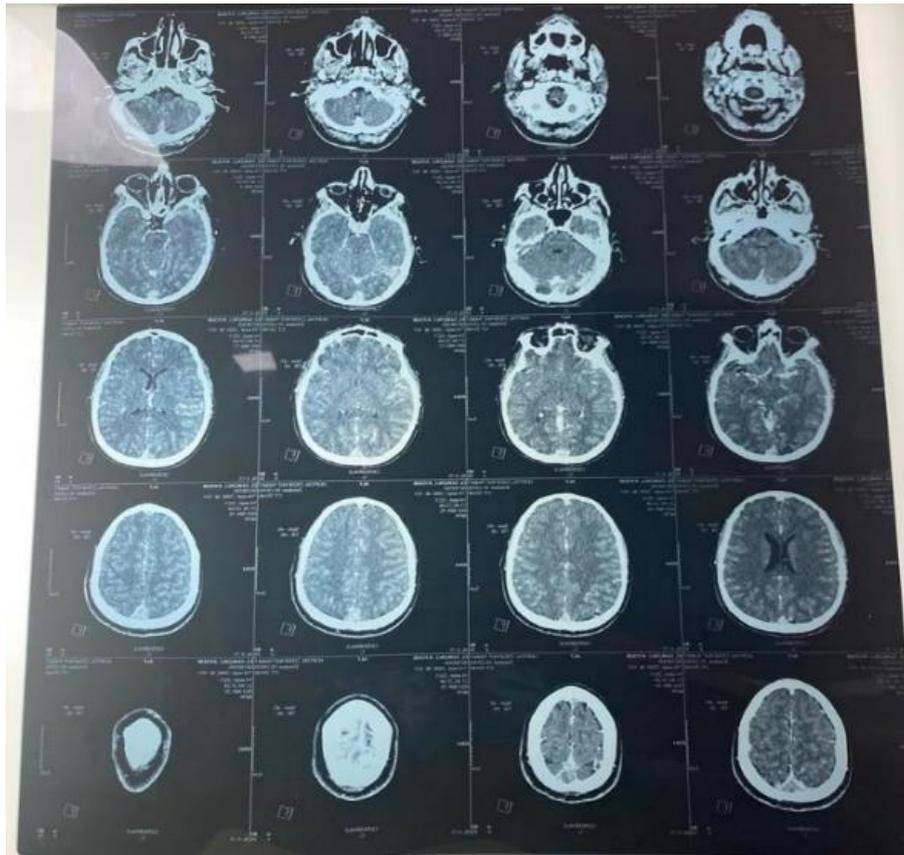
Brain CT showing meningeal enhancement.
